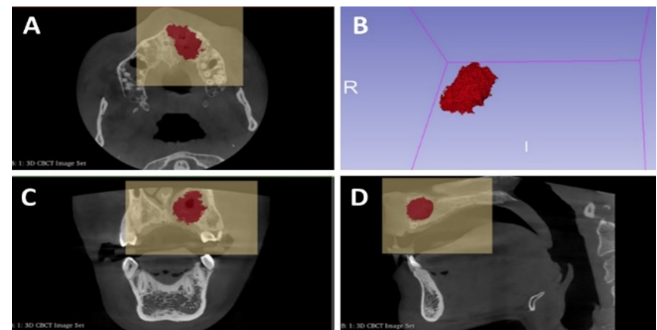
Cyst segmentation after marsupialization in an 18-year-old male patient. A: Axial cone beam computed tomography image showing the segmented cyst (red area). B: 3D reconstruction of the cyst. C: Coronal view of the lesion. D: Sagittal view demonstrating cyst extension.
